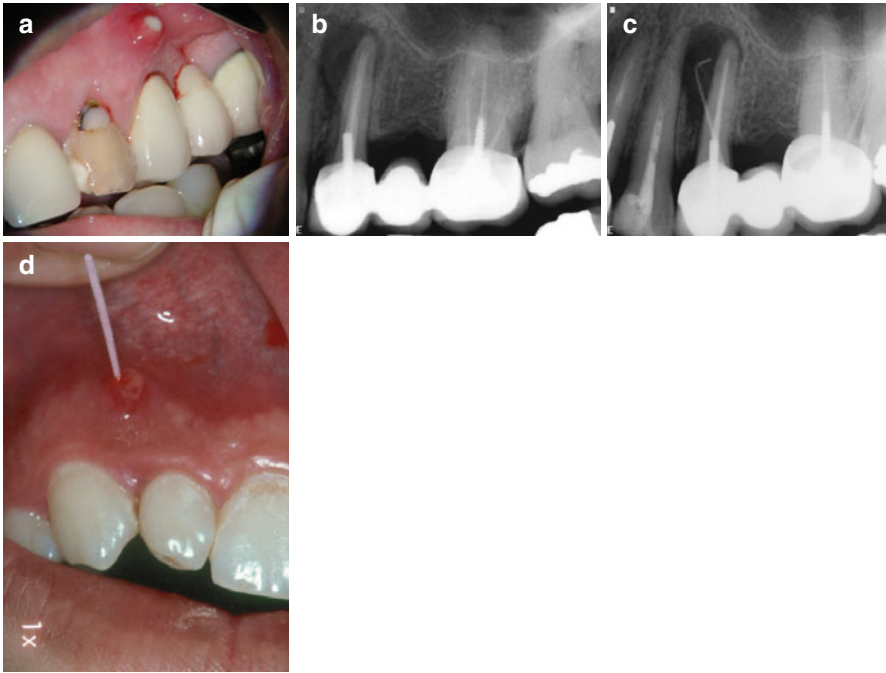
(a–d) The patient arrived at the dental office with a chief complaint of “a lump in the gum that comes and goes.” Upon examination, a highly located sinus tract was noticed in the second premolar attached gingivae (a) with some pus extruding on slight pressure. A narrow 9 mm probing defect was noted in the buccal aspect and no probing noted in the palatal side. The periapical radiograph revealed that the tooth was used as a mesial abutment for a three-unit bridge and that both the second premolar and first molar were endodontically treated (b). A large “halo”-type radiolucency can be seen in the mesial root aspect extending from the root tip of the root laterally to the coronal part. A gutta-percha tracing through the sinus tract extends to this area (c). In patients with chronic apical abscess in non-VRF cases, the sinus tract is located in the gingivae much closer to the apical area (d). The patient had clinical signs and symptoms that are pathognomonic for the diagnosis of VRF (a–c) (Courtesy Dr. R. Paul)
